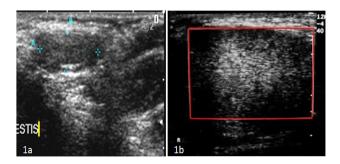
Cryptorchidism and torsion (a) Grey scale sonography shows left testis noted just near the left inguinal canal near the superficial inguinal ring, small in the size and hypo echoic in echo texture; (b)On Doppler study, no vascularity was noted in right testis, feature suggestive of torsion.
